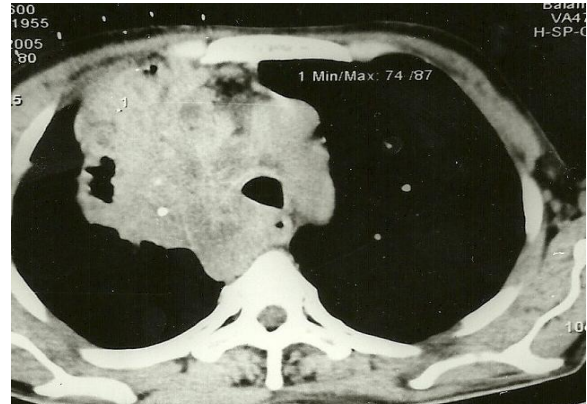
CECT chest showing cavitating mass in right upper lobe. CT axial section through upper chest demonstrates a cavitating mass in right upper lobe with mediastinal invasion.
